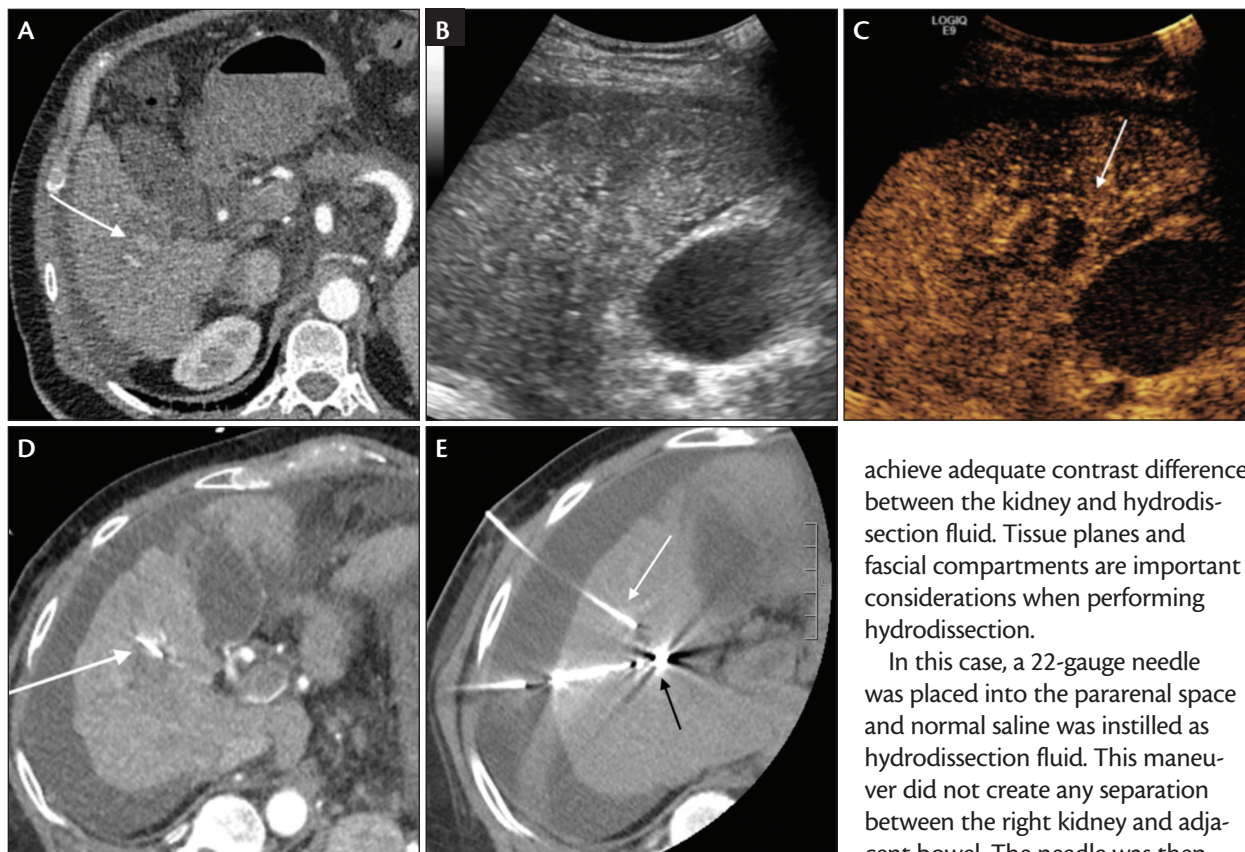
Arterial-phase CT demonstrated small enhancing tumor (A, white arrow) surrounded by parenchymal changes related to prior treatment. Grayscale ultrasound poorly demonstrated the tumor (B). Delay-phase contrast-enhanced ultrasound demonstrated clear washout (C, white arrow). CT during ablation with 22-gauge Chiba needle (D, white arrow) placed directly into the viable tumor using contrast-enhanced ultrasound guidance. CT during ablation showed microwave probe (E, black arrow) positioned using the 22-gauge Chiba needle (white arrow) as a landmark.
